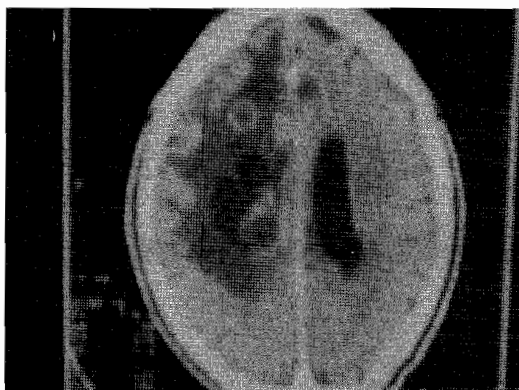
CT brain scan showing intracranial ring-enhanced lesions
